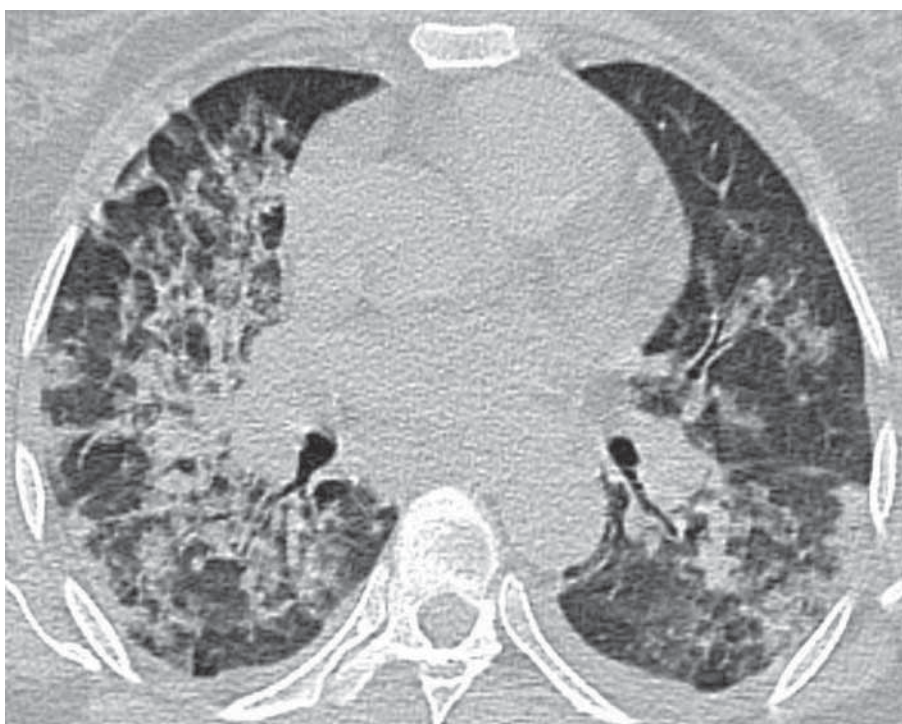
A 53-year-old patient with known type 2 diabetes mellitus presented with ongoing chest pain and cough. Follow-up CT performed 8 days after admission showed pleural effusion and white lung sign; CT-SS was 28.
